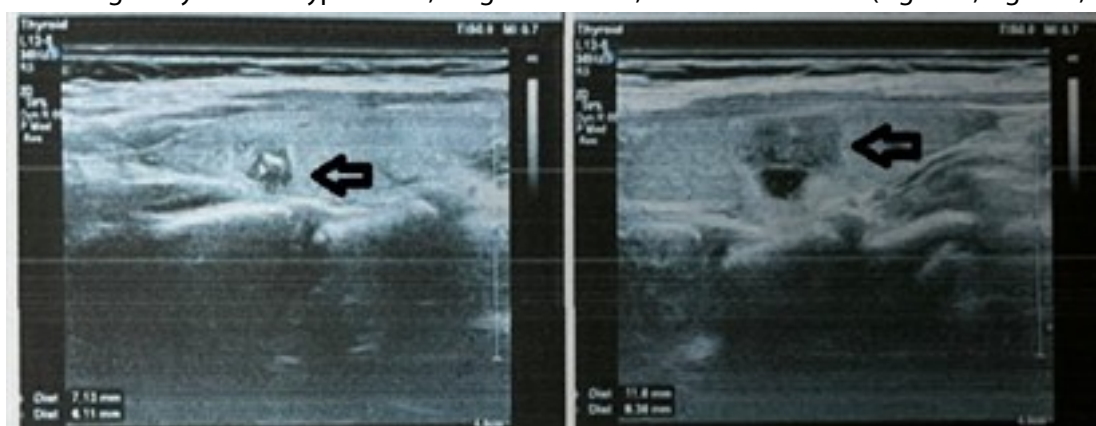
Ultrasound of thyroid nodule
